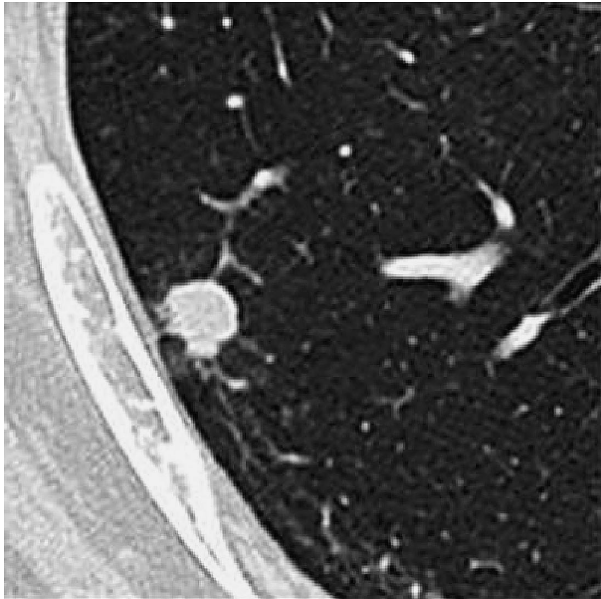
Thin slice CT scan obtained in a 70-year-old man shows a 10-mm mass with relatively smooth surface in the right lower lobe. Note that pleural retraction is also seen.
